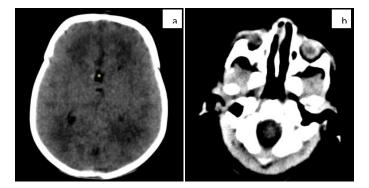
CT. Interhemispheric lipoma-like mass (asterisk) with minimal right peripheral calcification (a). Point of polyp insertion to the right side of the nasal septum (b).
